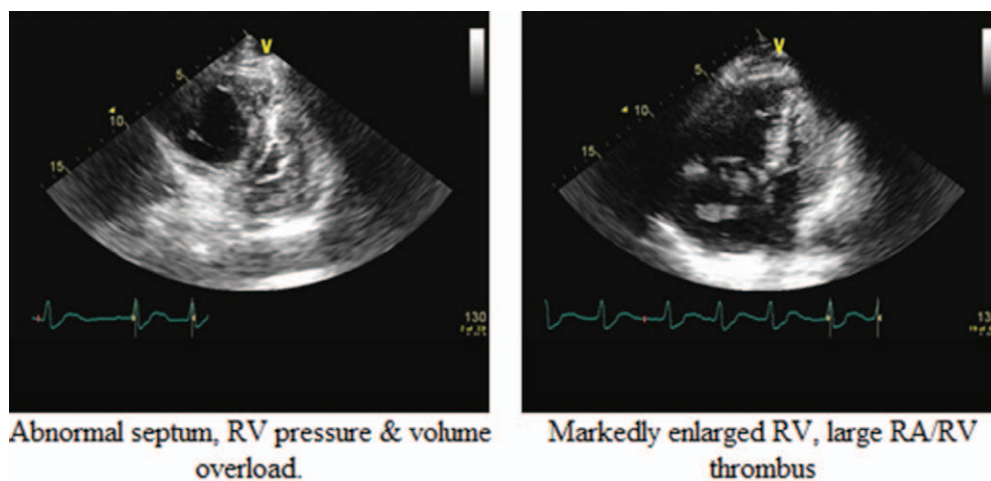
The bedside transthoracic echocardiogram showed the enlarged volume-overloaded RV and the thrombus on a standard short-axis parasternal view.
